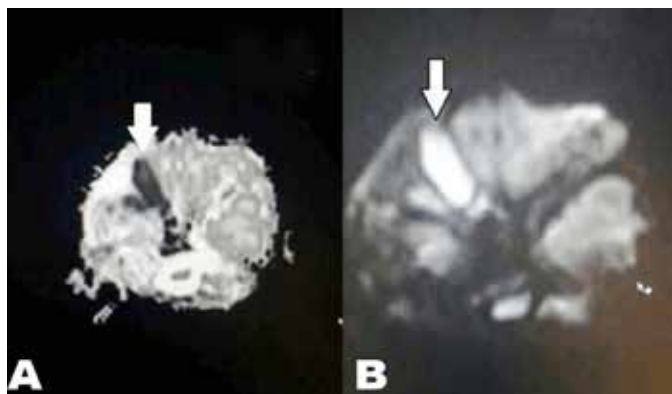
(A, B) Diffusion weighted magnetic resonance imaging orbit and brain revealing restricted diffusion in the right intraorbital extraconal mass suggesting orbital abscess (arrows).
